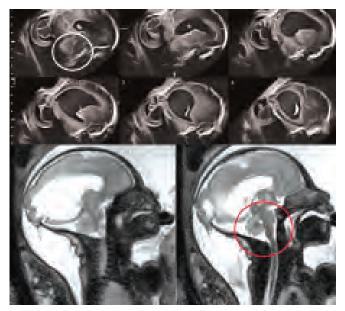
Tomographic ultrasound imaging (TUI) and MR imaging of the brain in a case of encephalomeningocele at 28 weeks of gestation. Prolapsed cerebral tissue with meninges are well demonstrated by both TUI (upper) and MRI (lower), but MRI indicates that the amount of cerebral tissue inside encephalomeningocele is quite little. Furthermore, in cases with encephalocele, the existence of Chiari malformation is important, and the brainstem and posterior fossa is more clearly depicted by MRI (red circle) than sonography (white circle). This case had no Chiari malformation
